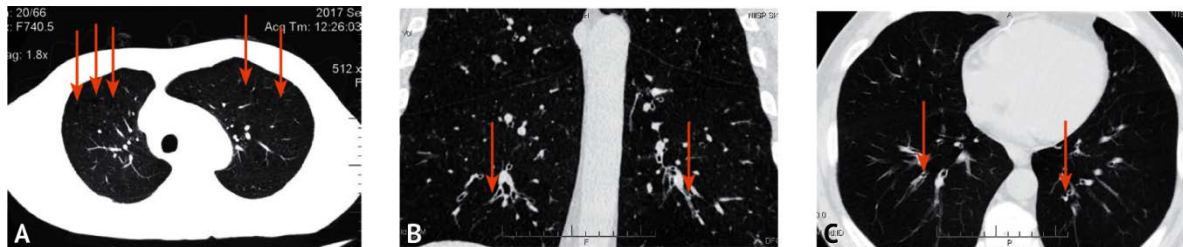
CT of the chest. A — Centrilobular emphysema in a patient with inhalation trauma; B — Frontal reconstruction. Multiple local areas of reduced density without visible walls are defined, clearly delimited from the unchanged pulmonary parenchyma in both lungs, mainly in the upper lobes, in the center of the secondary pulmonary lobules. The number of vessels and their diameter in these areas are reduced. Arrows indicate the thickened walls of the segmental bronchi; C — Axial slice. Computed tomography of the chest. Arrows indicate the thickened walls of the segmental bronchi
